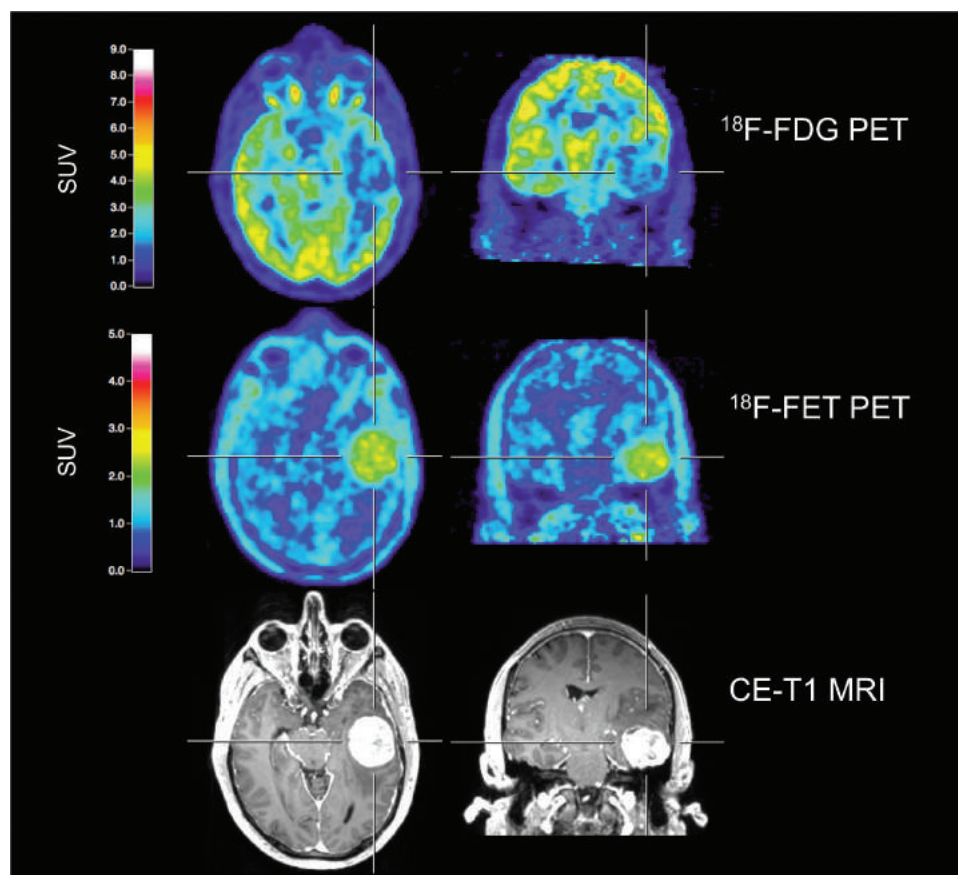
A 43-year-old male patient with a newly diagnosed left temporal meningioma (WHO grade I), preoperatively examined by multimodal imaging. Both contrast-enhanced MRI and ^{18}F -FET PET allow a precise tumor delineation. Conversely, ^{18}F -FDG PET shows decreased metabolic activity, indicating its limitation for the evaluation of meningioma extent.
